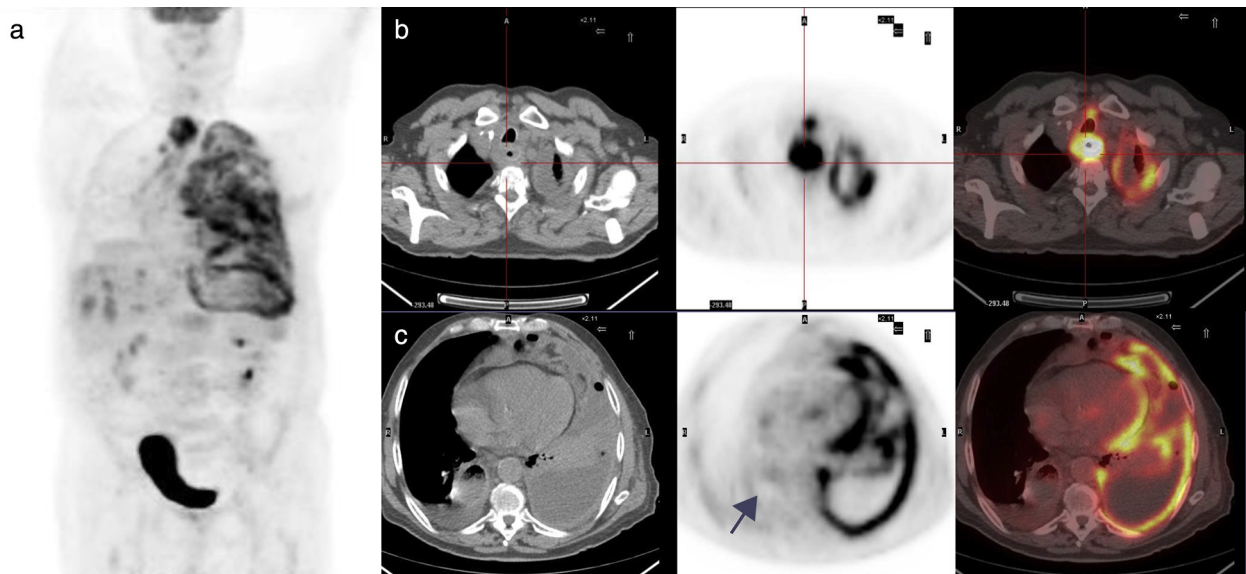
$^{18}\text{F}$ -FDG PET/TC at diagnosis. Maximum-intensity-projection (a), axial (b) and sagittal (c) PET/CT images show increased uptake in proximal esophagus due to esophageal carcinoma, without lymphadenopathy or distant metastasis.
